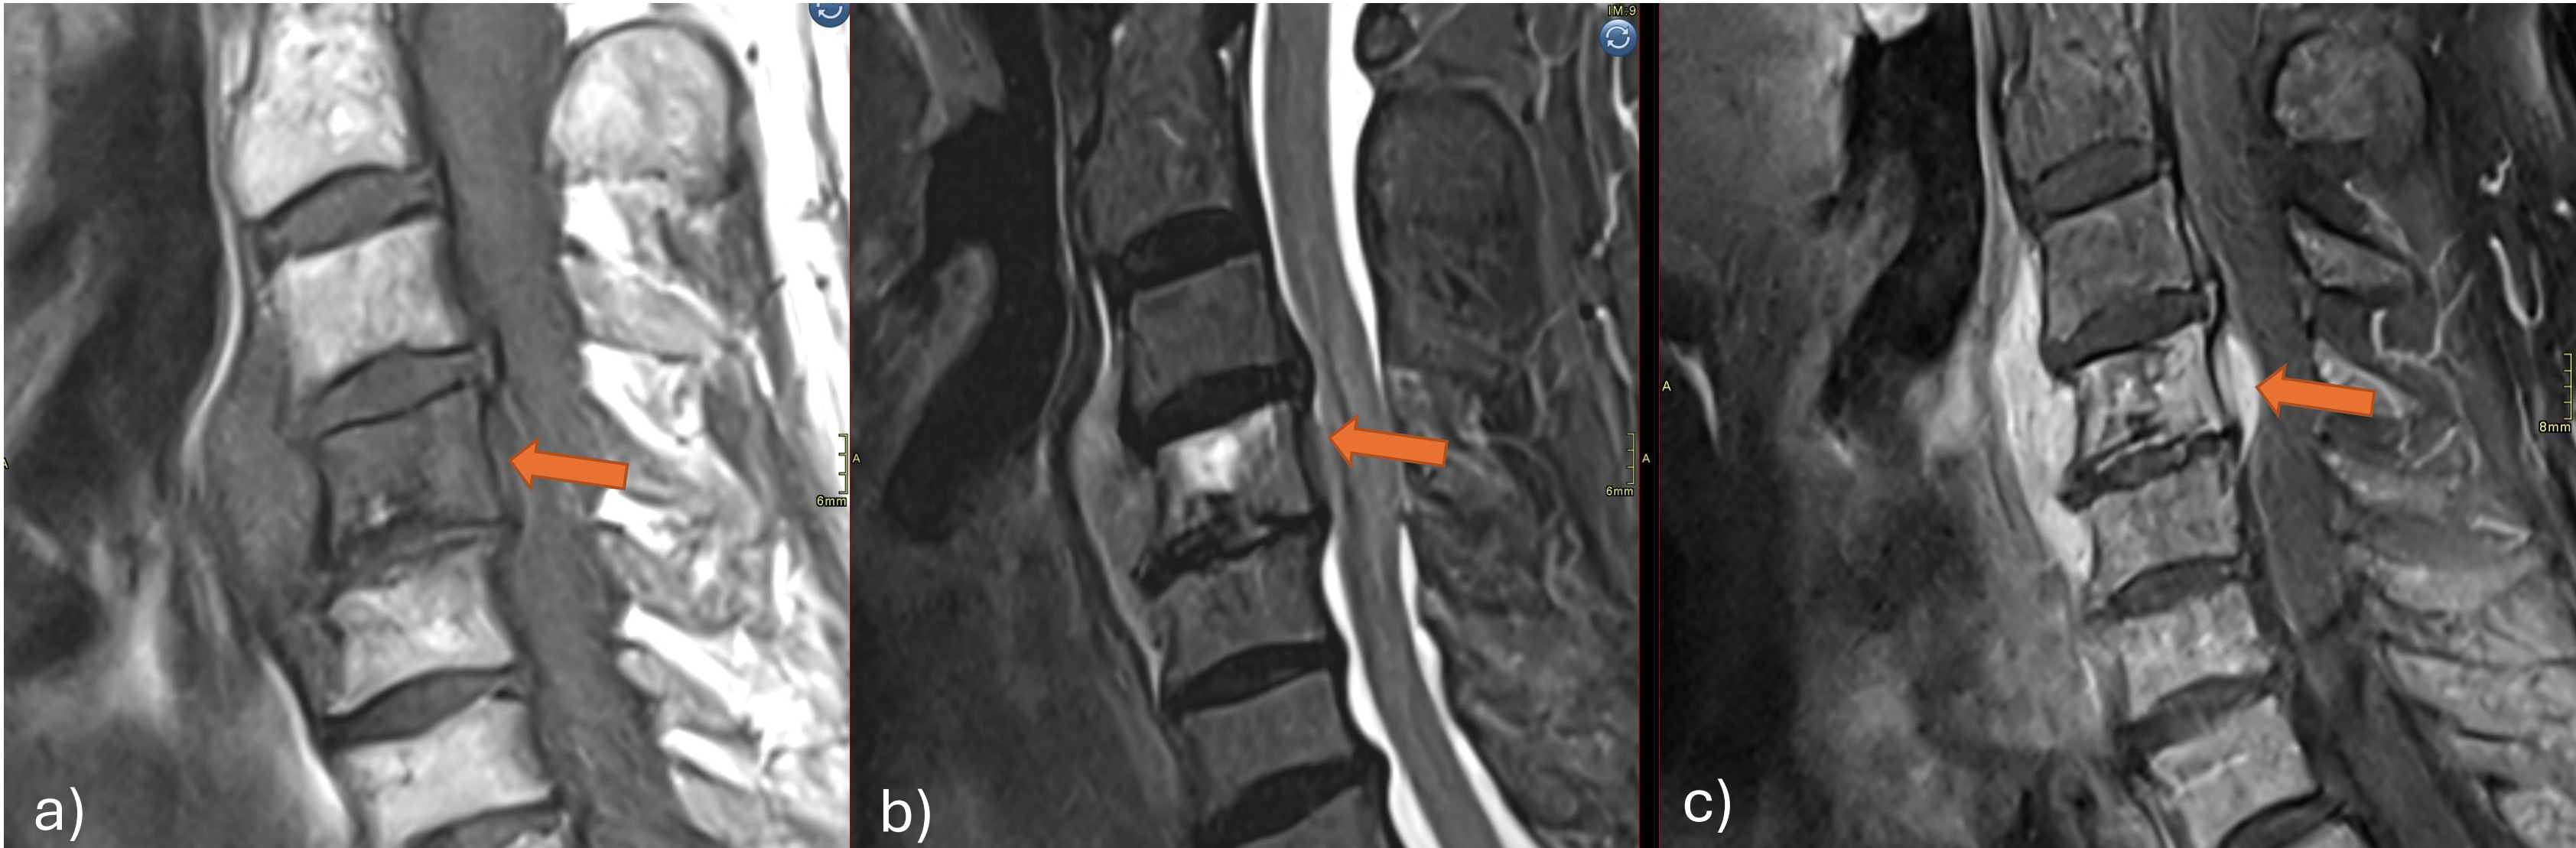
Patient no. 1. Cervical spine MRI demonstrating pathologic infiltration of the C4 vertebral body. Sagittal planes. a) T1-weighted sequence: hypointense signal in the C4 vertebral body with an associated soft tissue component. b) T2 STIR sequence: hyperintense signal in the upper half of the C4 vertebral body. c) T1-weighted fat-suppressed sequence after contrast administration: contrast enhancement of the pathologic infiltration of the C4 vertebral body and the extraosseous tumor component at the C4 and C5 levels.
